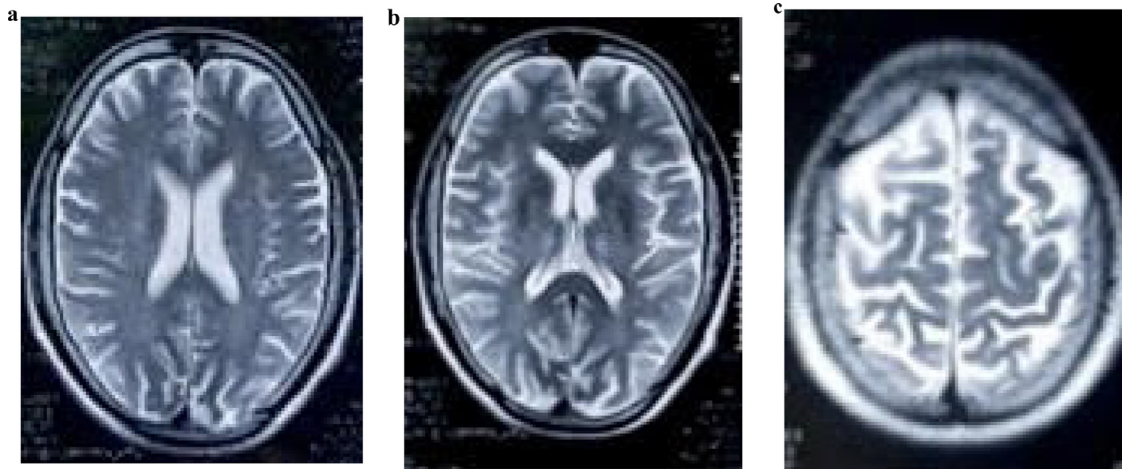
(A) Axial T2 magnetic resonance imaging (MRI) scan of the brain reveals altered signal intensity in the bilateral basal ganglia, appearing hypointense in the basal ganglia region. (B) Axial T2 magnetic resonance imaging (MRI) scan of the brain reveals altered signal intensity in the bilateral basal ganglia appearing hypointense in the external capsule and hyperintense in thalami. (C) Axial T2 magnetic resonance imaging (MRI) scan of the brain reveals hypointensity in the subcortical white matter.
